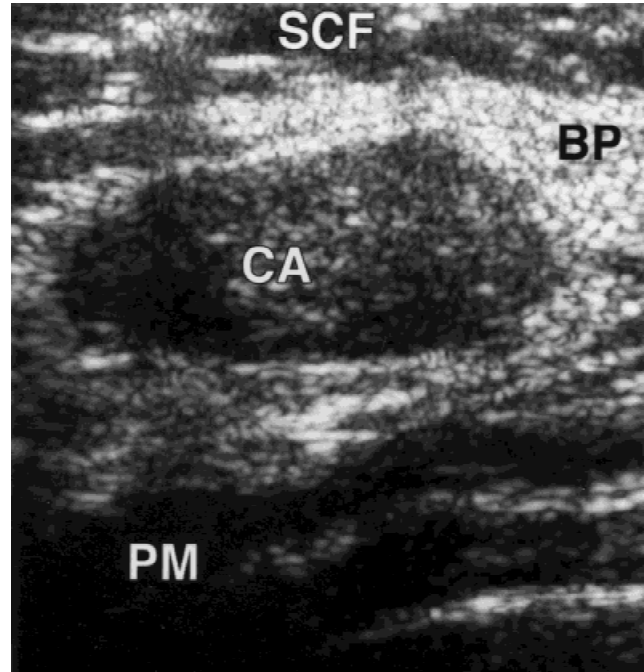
Ultrasound image of a 10-mm nonpalpable breast cancer. SCF, subcutaneous fat; BP, breast parenchyma; CA, carcinoma; PM, pectoral muscle.
